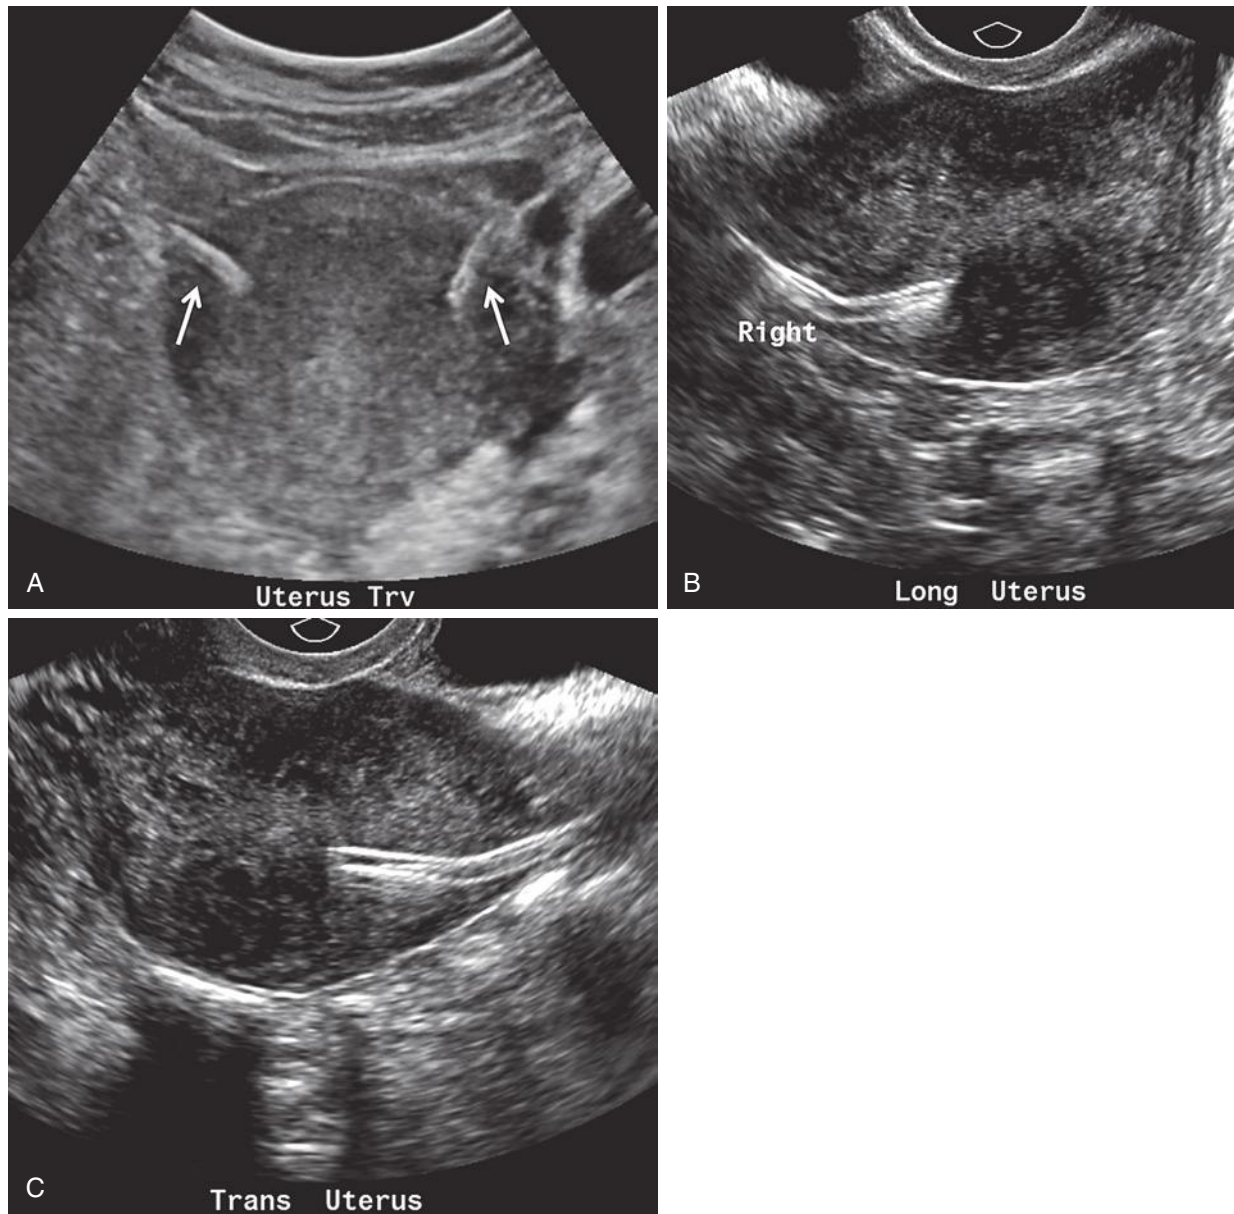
Normal ultrasound appearance of Essure device. A, Transabdominal image of the uterus demonstrates Essure microinsert birth control devices. On this coronal view through the uterine fundus, bilateral, slightly curved linear echogenic foci are seen (*arrows*), indicating normal device placement within the interstitial segment of the fallopian tube on each side. On transvaginal sonographic images, the right (B) and left (C) Essure devices can be seen extending from the interstitial portion of the fallopian tube into the isthmic segment. (Courtesy Department of Obstetrics and Gynecology, Yale University School of Medicine, New Haven, CT.)
